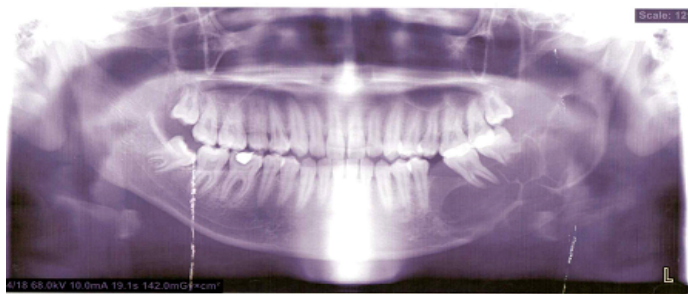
Initial panoramic radiograph shows well-defined multilocular radiolucency with scalloped-corticated border from the left body of mandible extend to the ramus
